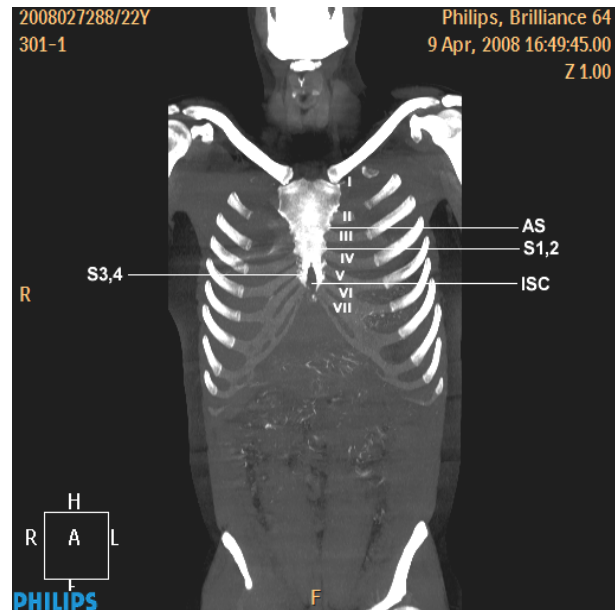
Computed tomographic chest roentgenogram with three-dimensional reconstruction that revealed costal variation clearly. The manubrium sterni and corpus sterni received I.–II. costal cartilages and IV.–VII. respectively. And, the angulus sterni received III. costa cartilagine instead of II. costa cartilagine (AS: angulus sterni; S1,2: first and second sternbrae; S3,4: third and fourth sternbrae; ISC: inferior sternal cleft; I–VII: costae I–VII).
